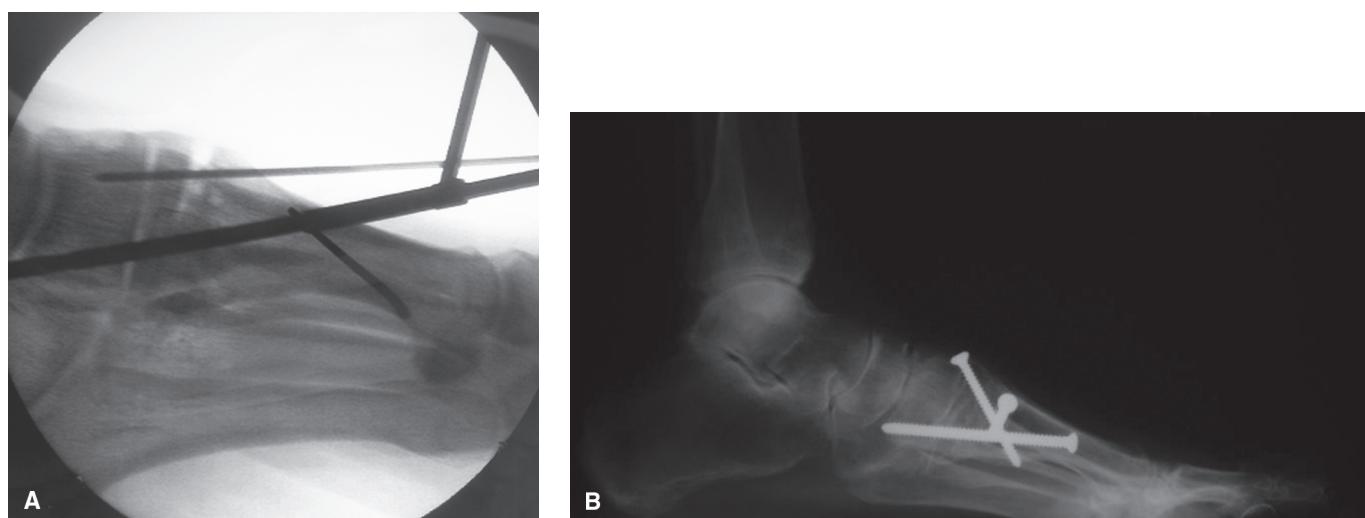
Intraoperative radiograph in a case in which a large Weber clamp was used for reduction of a large IM angle.
